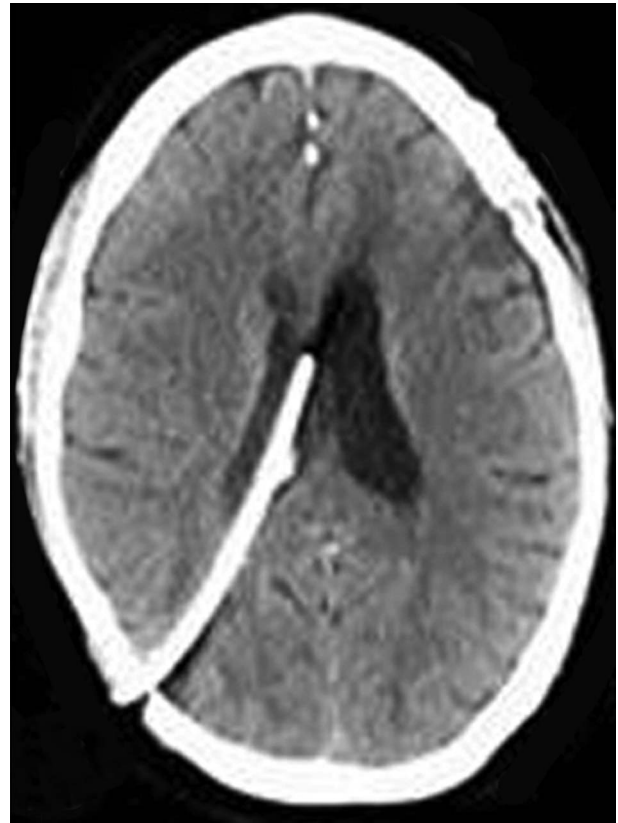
Computed tomography 12 days postoperatively reveals a pericatheter cyst in the right in the right occipital lobe.
